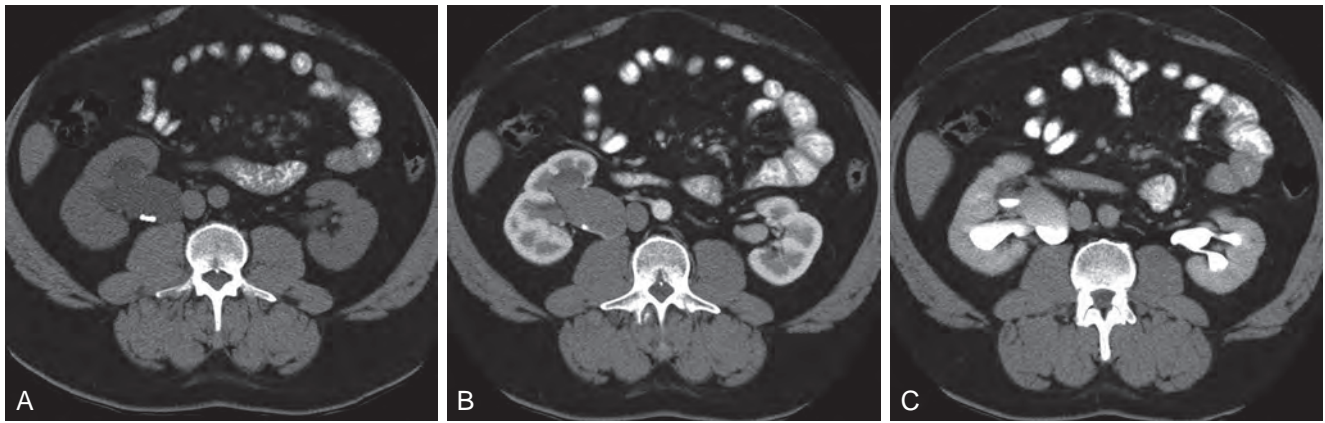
A, Contrast-enhanced computed tomography scan identifies a classic ureteropelvic junction (UPJ) appearance in early-phase imaging. B, Early images reveal normal nephrogram and delayed filling of the obstructed, dilated UPJ. C, Delayed images demonstrate holdup of contrast drainage on the right compared with the normal left side.
